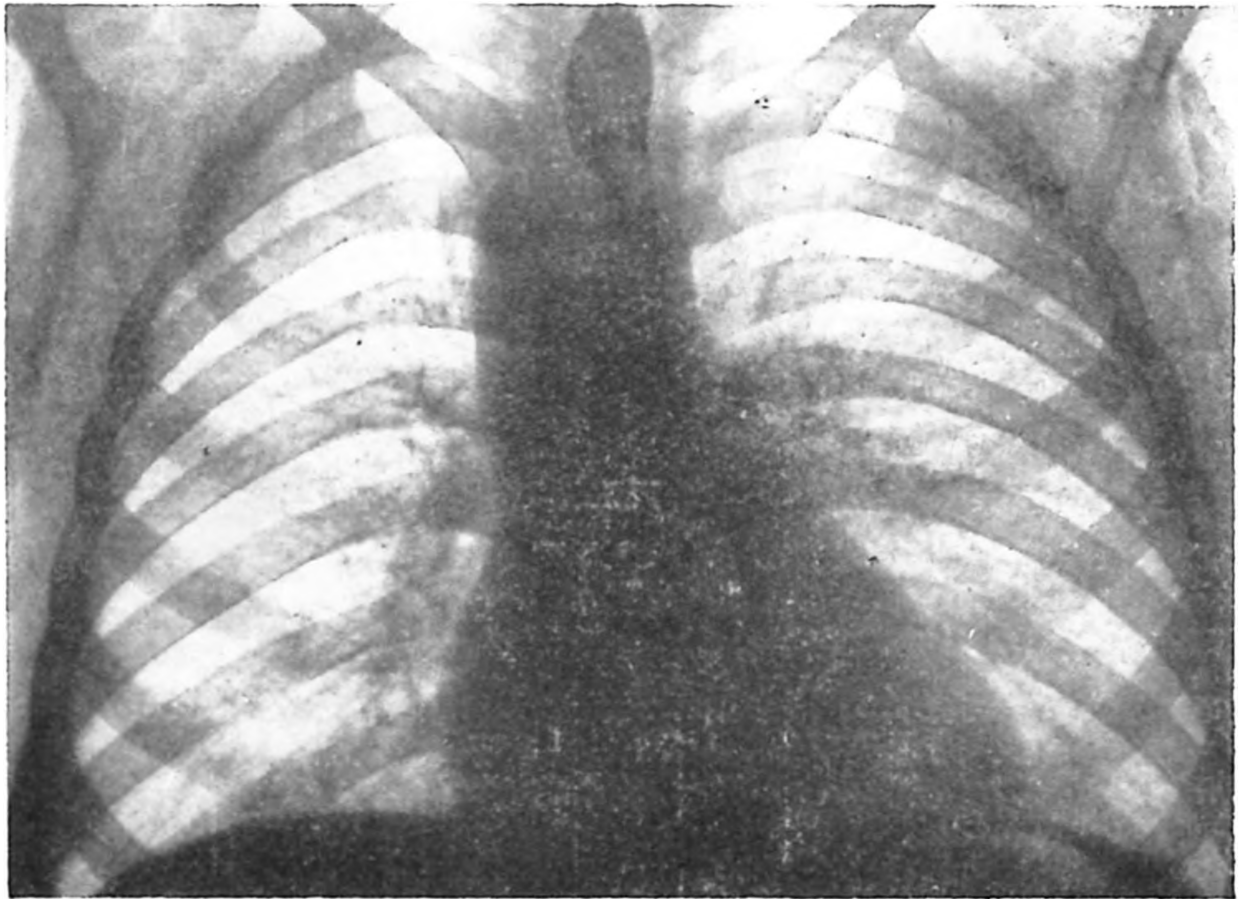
Another roentgenogram with barium swallow showing aortic arch on the right side.
